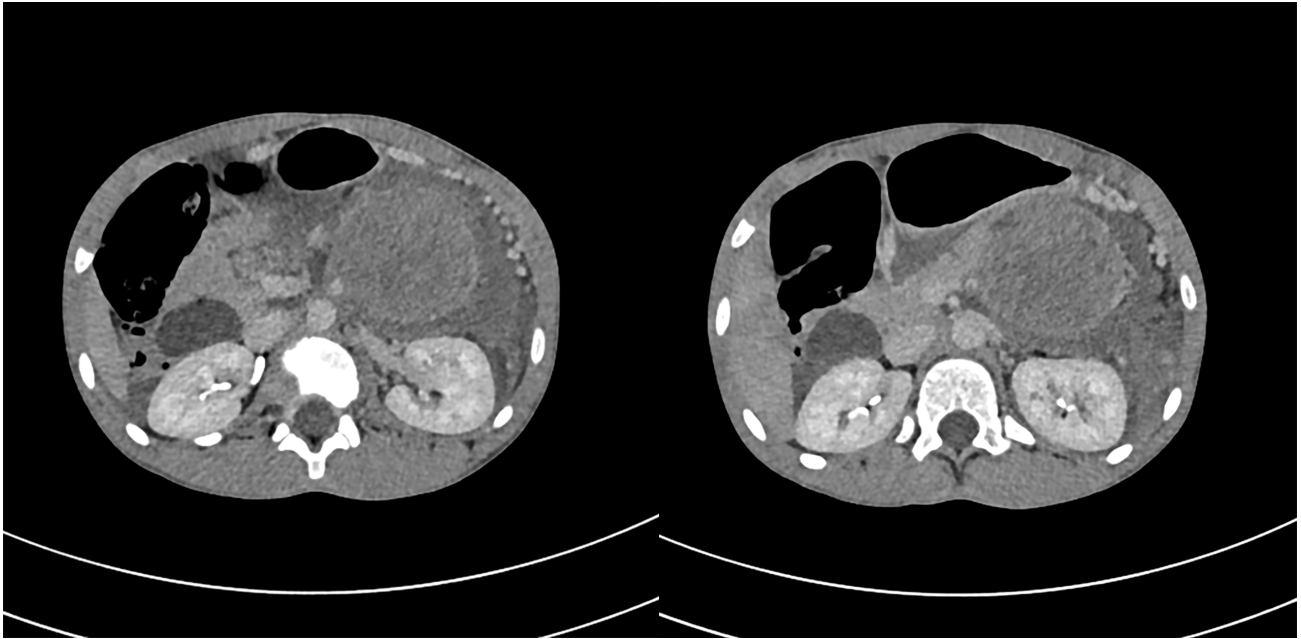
Axial views of the abdominal CT scan showing the pancreatic tumour, peri-pancreatic haematoma and limited varices in the periphery of the tumour
